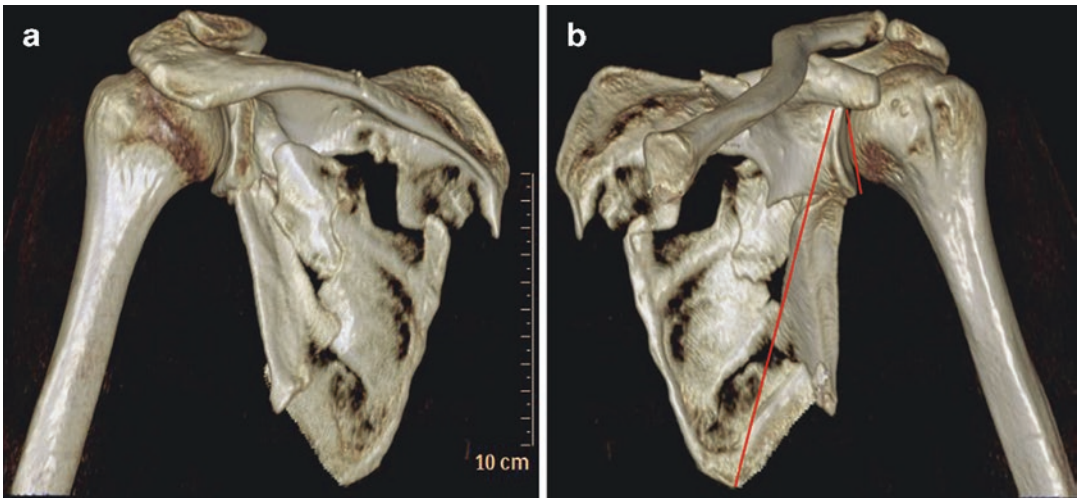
(a, b) 3D CT reconstruction (a) of the scapula. The 3D CT reconstruction is useful to aid in assessment of the glenopolar angle (GPA) and fracture pattern (b) (see
